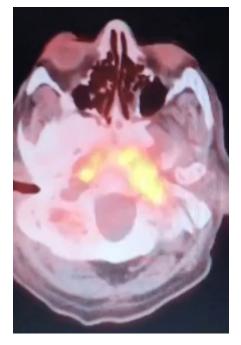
Positron Emission Tomogram (PET) Computer Tomogram (CT) showing hypermetabolic foci in bilateral petrous apex
